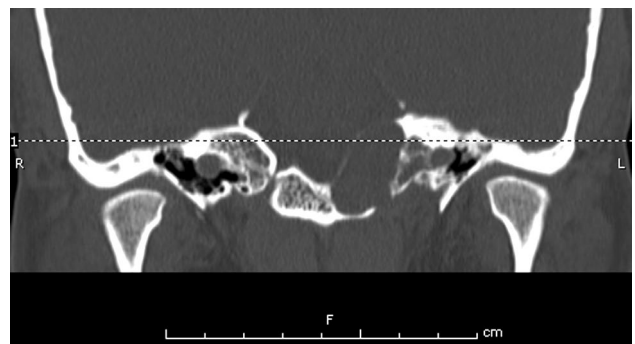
Temporal bone computed tomography (sagittal) showing a large, erosive and destructive lesion in the petrous apex.
